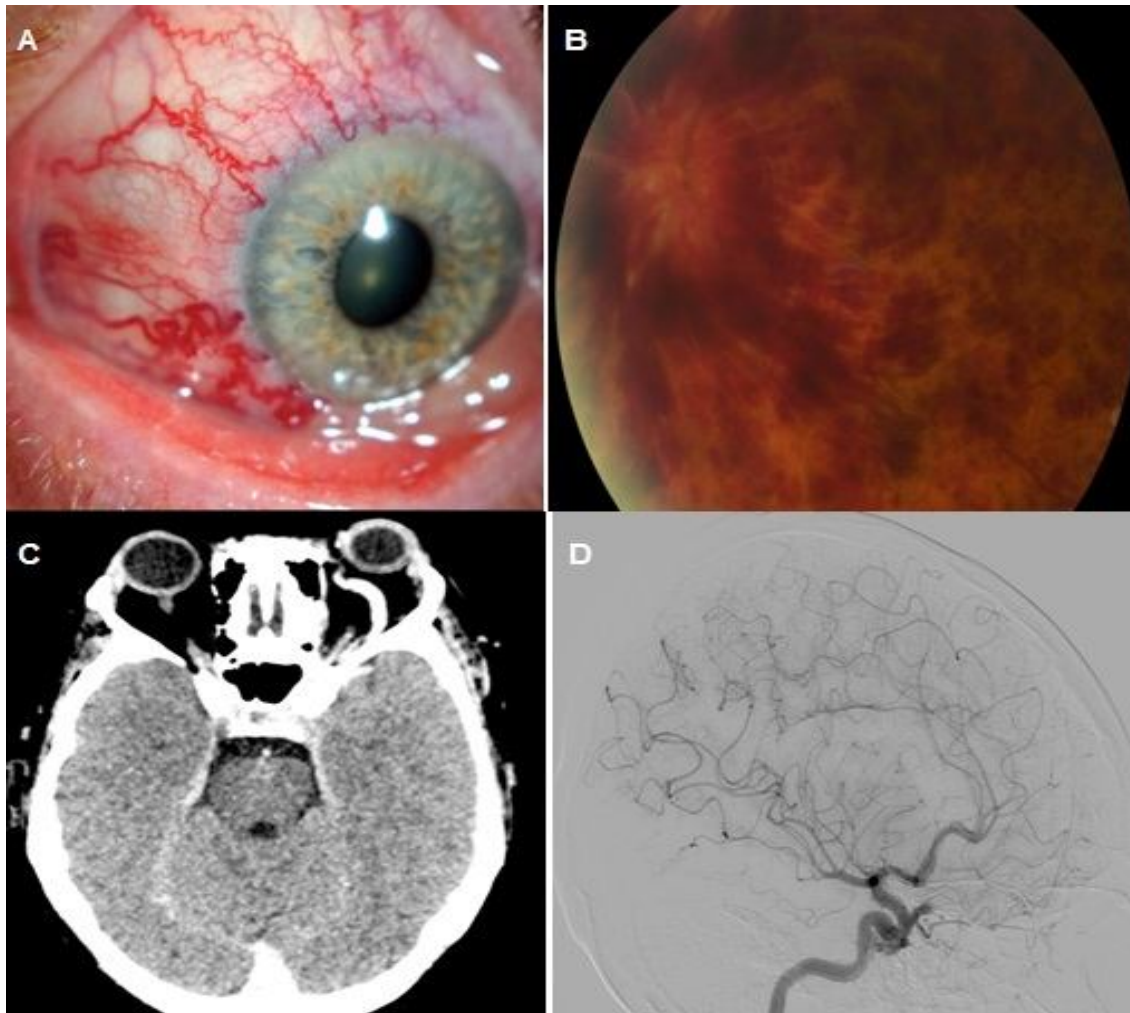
external ocular photography showing conjunctival injection with corkscrew vessels (a) fundus photography showing central retinal vein occlusion (b) axial CT-scan showing enhancement of the superior ophthalmic vein in the arterial phase of injection with an abnormally dilated and tortuous aspect (d) lateral view of catheter arteriography demonstrating rapid enhancement of the left cavernous sinus and left superior ophthalmic vein.
